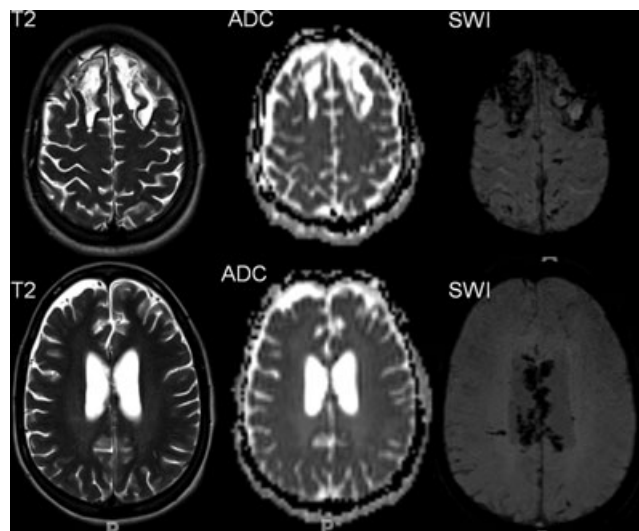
Axial T2, ADC, and SWI MR images of a 16-year-old female with diffuse axonal injury after high-speed motor-vehicle accident. Images are acquired several months after trauma. CSF filled T2-hyperintense (high ADC values) brain defects are noted within both frontal lobes. SWI is especially helpful to identify the extensive hypointense shear injuries within the corpus callosum as well as the blood products along the periphery of the brain defects. SWI shows, in addition, multiple small cortical/subcortical petechial hemorrhagic shear injuries.
